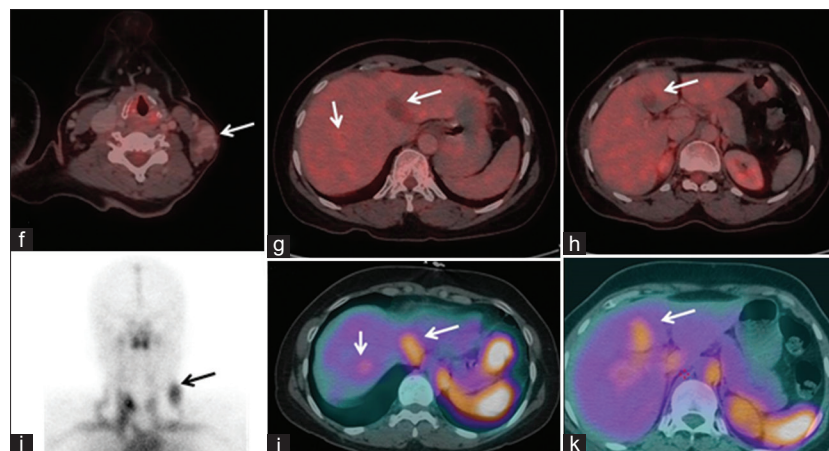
Upper row axial hybrid PET CT images reveals no metabolic activity in the vascular malformations in f) left sided posterior triangle of neck with g) segment IVa & VIII of liver and h) IVb liver lesions. The corresponding Tc-99m RBC images i), j) and k) show focal increased tracer uptake confirming haemangiomas
